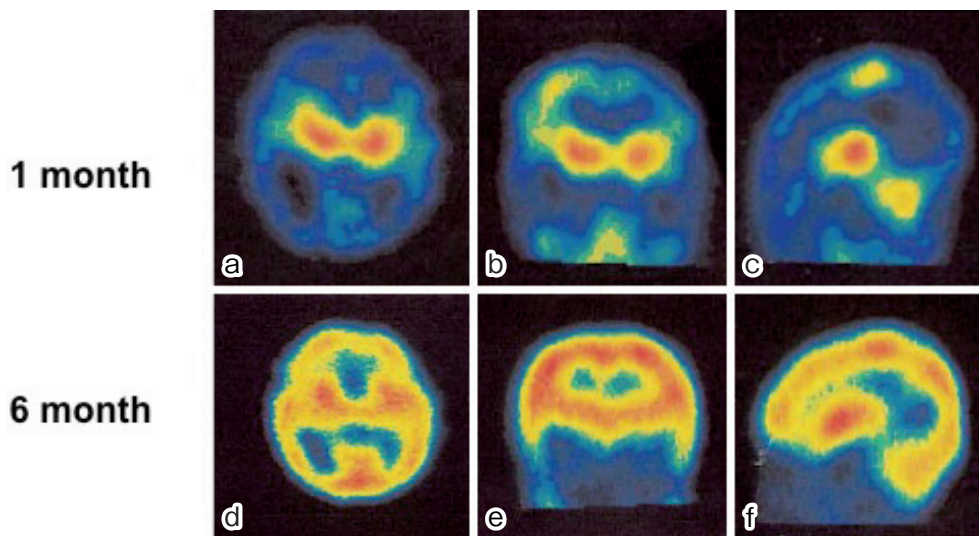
Single-photon emission computed tomography (using isopropyl-p-[¹²³I]-iodoamphetamine) was performed at 1 month (before treatment) (a-c) and 6 months (after treatment) (d-f). (a) and (d) are axial images, (b) and (e) are coronal images, and (c) and (f) are sagittal images.
